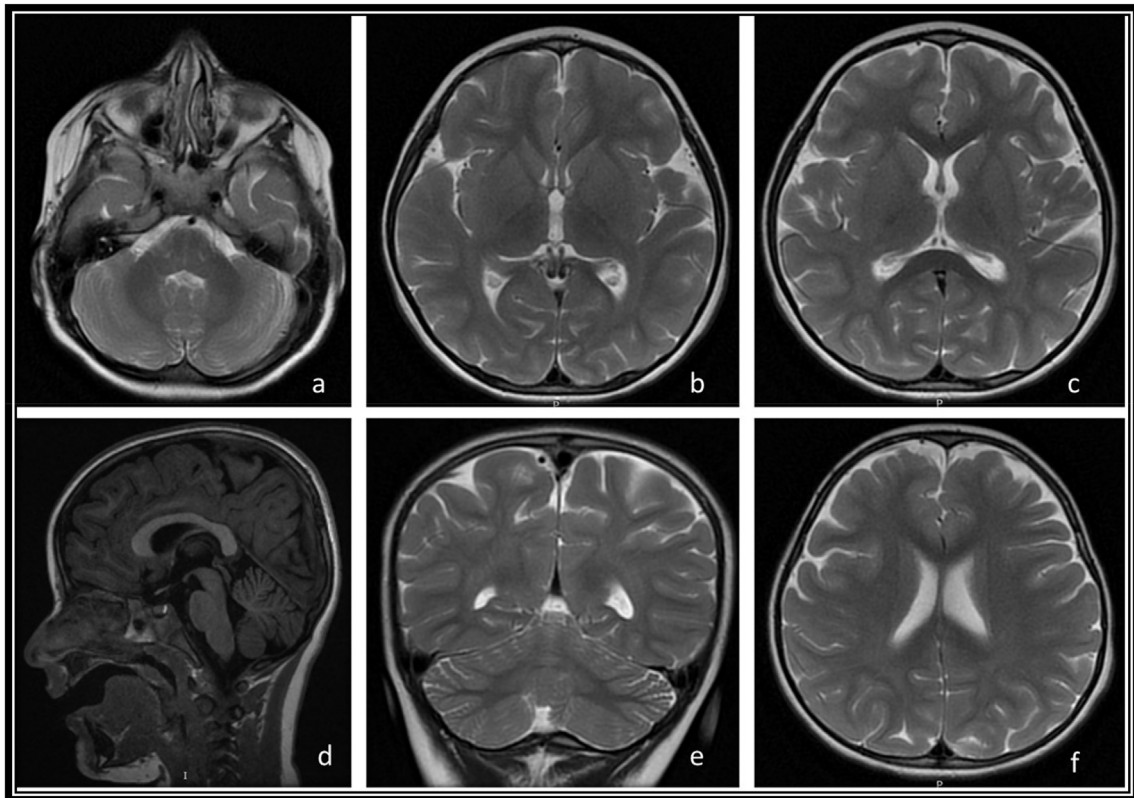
Patient 5 – T2-weighted axial sections (a, b, c, f), T2-weighted coronal section (e) and T1-weighted sagittal section (d) from an MRI scan taken at the onset of symptoms. This MRI scan is normal (a, b, c, d, e, f).
